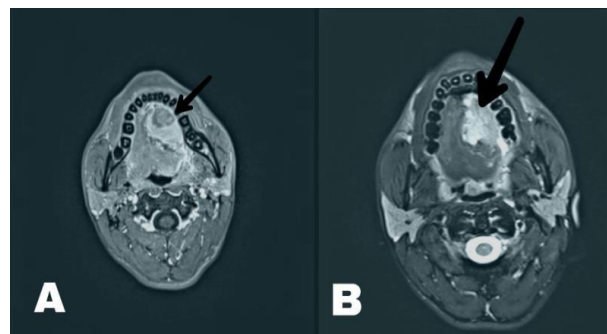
(A) Contrast-enhanced T1 weighted (B) T2 weighted axial section MRI showing hyperintense lesion in anterior 2/3rd of floor of mouth and going to lateral border of tongue on left side.
